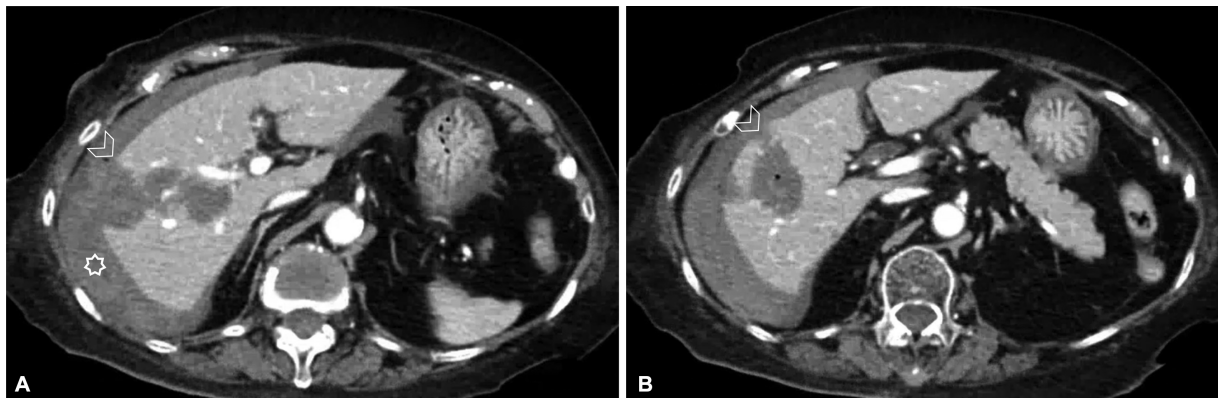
Computed tomography angiography (CTA) abdomen immediately after completing the procedure shows perihepatic hematoma and post-liver ablation changes. (A) Second liver capsule puncture site (arrowhead) after reablation without residual active bleeding with perihepatic hematoma (asterisk) and (B) first liver capsule puncture site (arrowhead).
